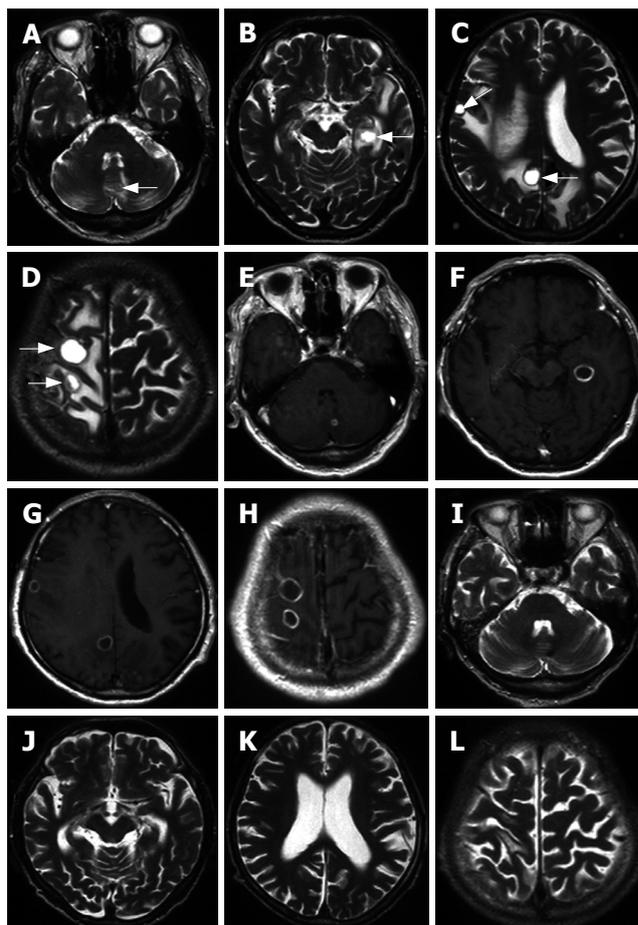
Unenhanced T2-weighted MR images show hyperintense tumors in the cerebrum and cerebellum (arrows) (A, B, C, D). Contrast-enhanced T1-weighted MR images show ring-shaped enhancement of the tumors (E, F, G, H). On T2-weighted, unenhanced MR images, captured 3 mo after the completion of radiotherapy, the brain tumors have almost completely disappeared (I, J, K, L).
